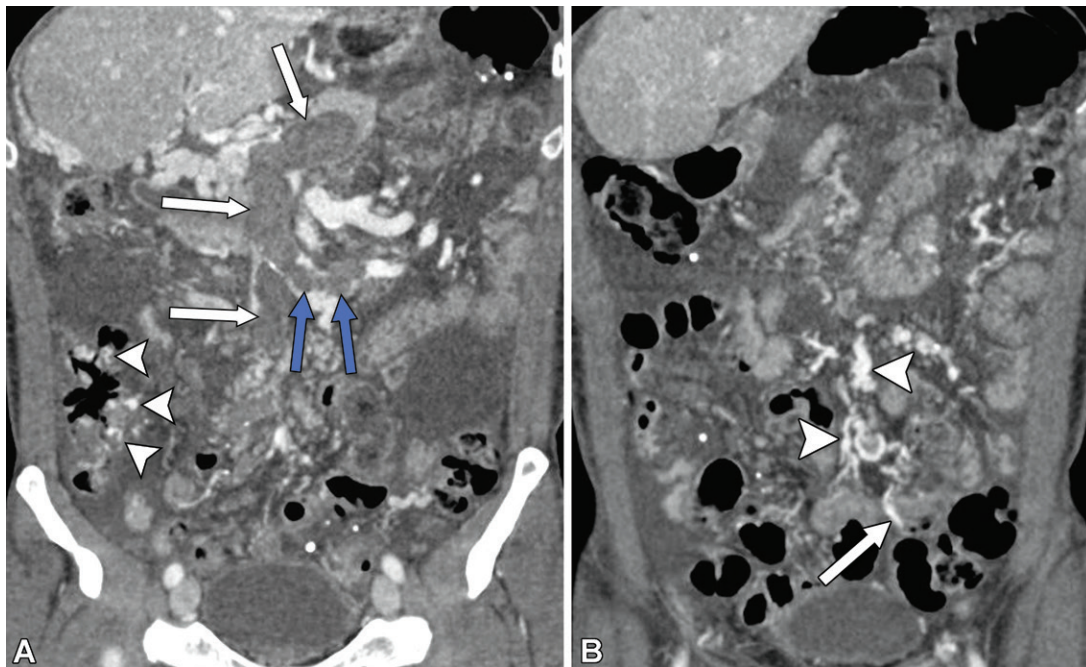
Ectopic varices in the small bowel and colon resulting from acute superimposed on chronic thrombus in the portal venous system in a 58-year-old man who presented with abdominal pain, melena, and a new hemoglobin level decrease. Coronal portal venous phase CT images show acute thrombus throughout the superior mesenteric vein and its tributaries (white arrows in A), extending into a surgically placed splenorenal shunt (blue arrows in A). Also noted are multiple varices in the right colon (arrowheads in A). There are multiple associated mesenteric venous collaterals (arrowheads in B) as well as small bowel varices (arrow in B).
